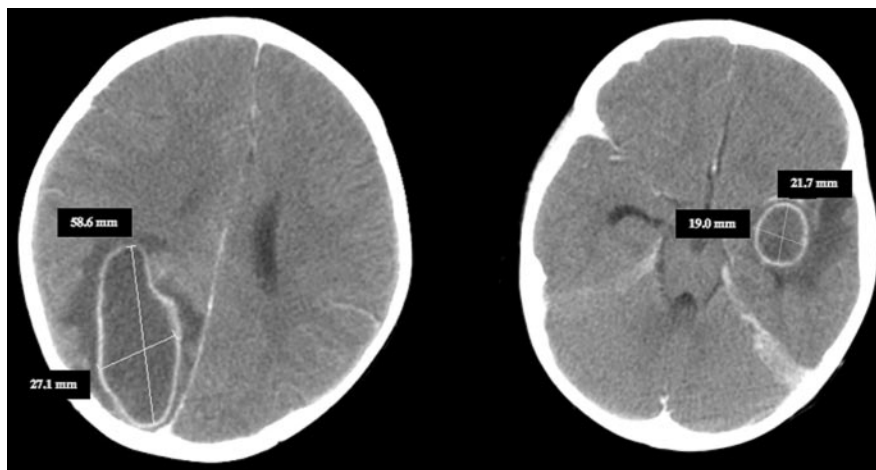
Head CT scan with intravenous contrast performed on the day of admission. The image on the left shows an abscess collection measuring 58.6 by 27.1 mm in the right posterior parietal region; the image on the right reveals an abscess measuring 21.7 by 19.0 mm in the left temporal lobe.
